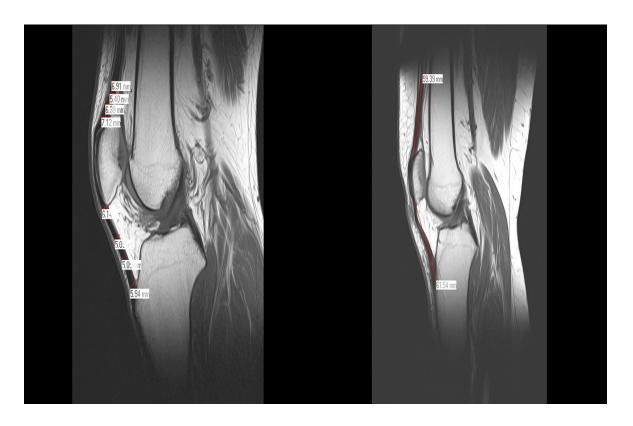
Shows example of data collection taken from Q1,Q2,Q3,Q4 and P1,P2,P3,P4 and P length at sagittal T1 MRI of the knee joint .
